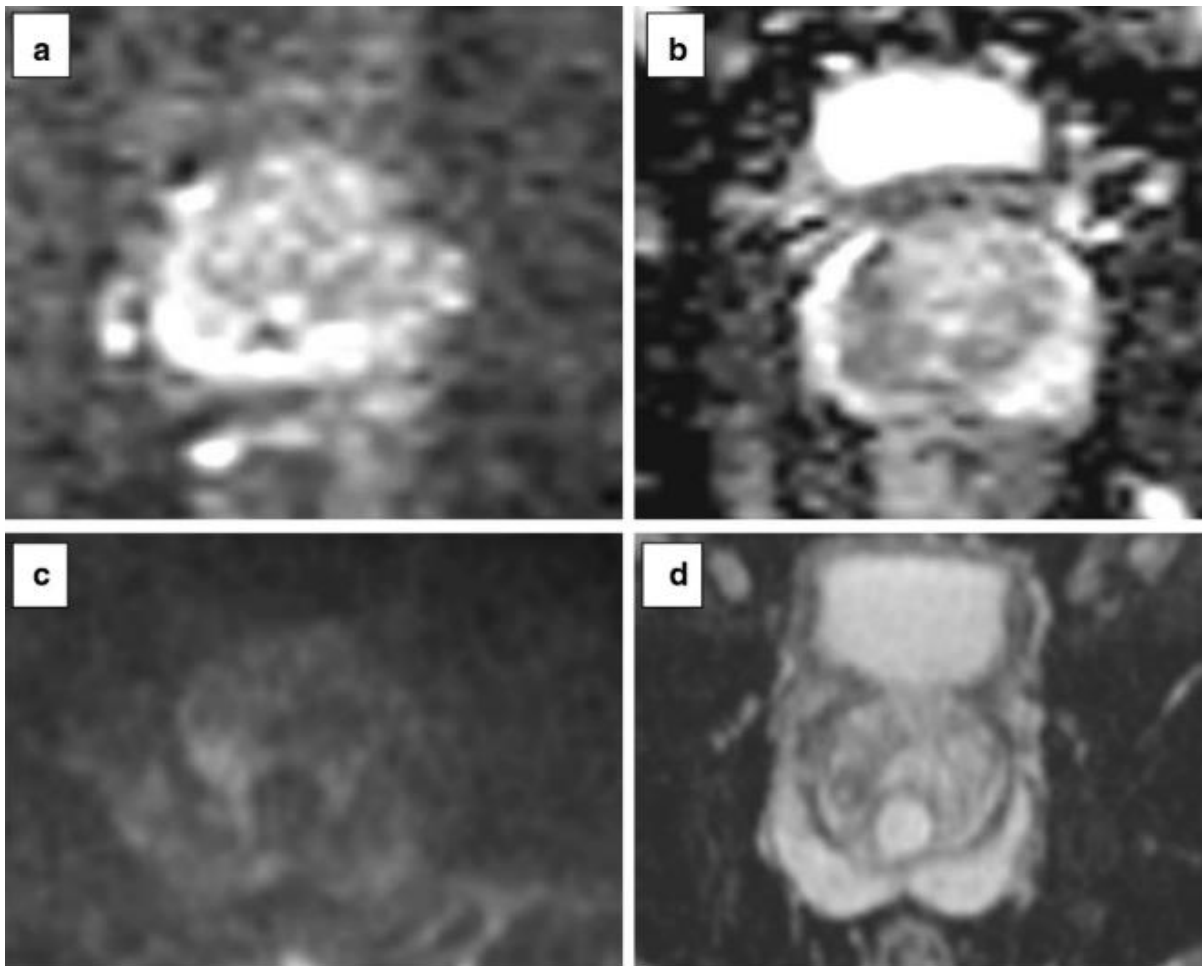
DWI suboptimal (a, b) and optimal (c, d) in plane resolution for the high b sequence (a, c) and ADC map (b, d) respectively ((9)
